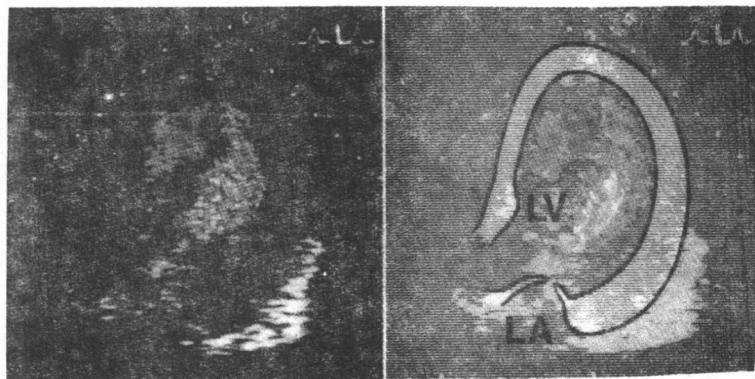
Color-coded 2-D Doppler echocardiogram, parasternal long-axis view, of a patient with valvular mitral stenosis. The transmitral jet is shown in color. *LV* indicates left ventricle; *LA*, left atrium.
